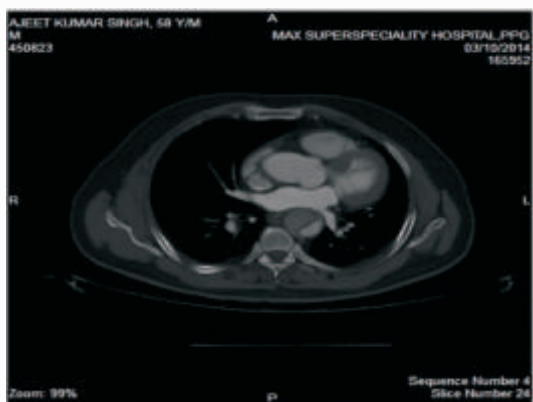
CT- Angiogram: Markedly compressed true lumen of descending thoracic aorta
